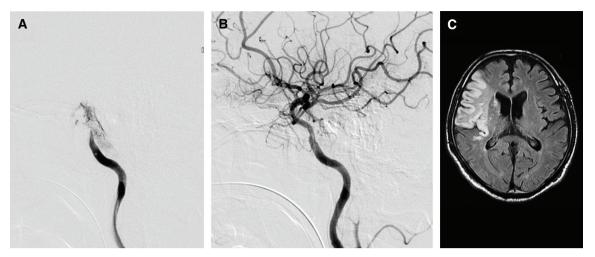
Case 2: (A and B) Lateral images of right internal carotid angiography (A: before thrombectomy and B: after thrombectomy) and (C) DWI of head MRI on the day after thrombectomy. DWI: diffusion-weighted imaging, MRI: magnetic resonance imaging
